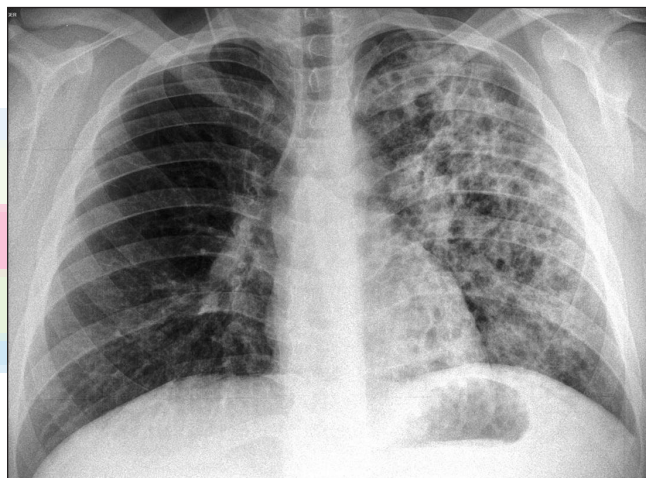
An increase of infiltrations in the control PA radiography.
